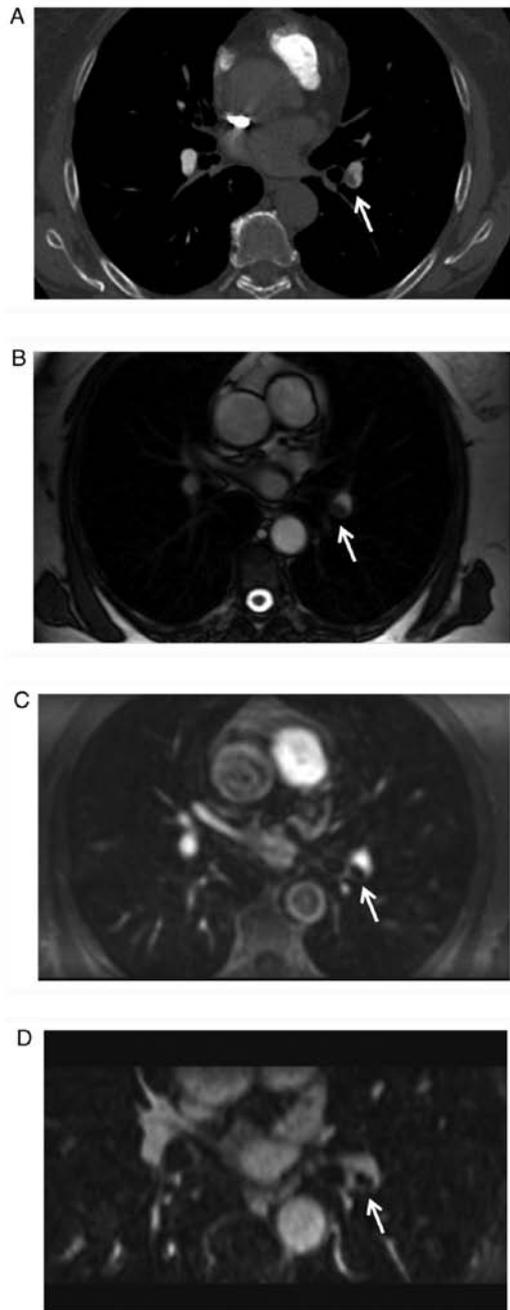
Representative case of a 63-year-old male with leg pain and chest congestion. (A) CT pulmonary angiography revealed the pulmonary embolus at the truncation of the segmental pulmonary artery in the left lower lobe (arrow). (B-D) Axial images of (B) true fast imaging with steady-state precession, (C) contrast-enhanced MR pulmonary angiography and (D) enhanced volume-interpolated body examination displayed the embolus depicted in A clearly (arrows).
